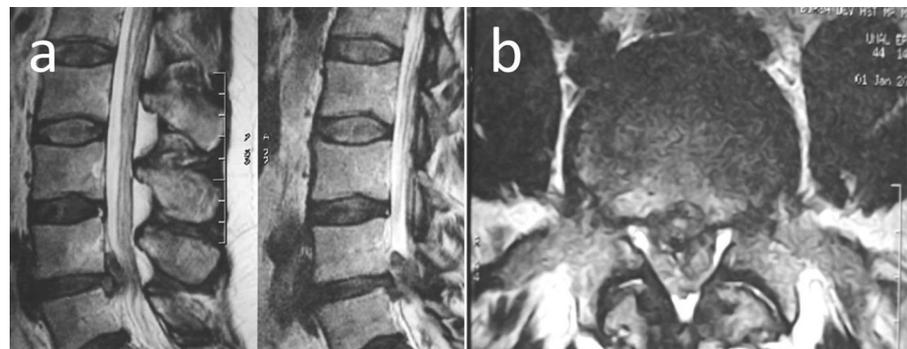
(a) The sagittal T2-weighted image of the initial MRI study reveals a large herniated disc at the L4–5 level with caudal migration (January 2010). (b) Axial T2-weighted image of the initial MRI shows a left side posterolateral extruded disc fragment (January 2010).
